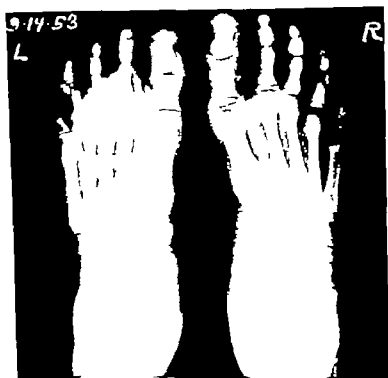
W. H. Uncorrected deformity of the fore part of the foot in a case of clubfoot. A, Roentgenogram of both feet made July 10 1953 showing adduction deformity of the left foot when the boy was 5 years old. B, Roentgenogram of both feet made Sept. 14 1953 immediately after postoperative cast was removed, nine weeks after anterior capsulotomies. Note that the superimposition and apparent arsis or i ward twisting of the middle three metatarsals are no longer present. (From Heyman, C. H. Herndon, C. H., and Strong, J. M. *J. Bone & Joint Surg.* 48-A: 299, 1958.)
